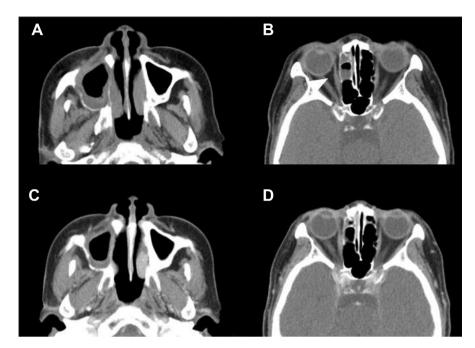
(A and B) A month after additional chemoradiation therapy ended, follow-up CT was suggestive of residual tumor in the ethmoid sinus. But the pathological analysis was negative for tumor. (C and D) Recent CT images of the patient, there were no evidence of tumor recurrence or metastasis in the local or regional areas.
